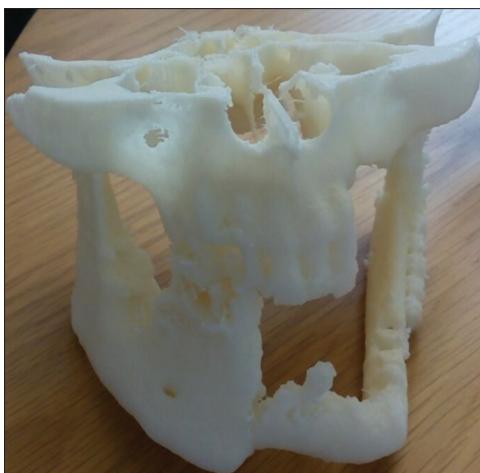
3-D print of craniofacial structure in cancer patient after computed tomography scan
